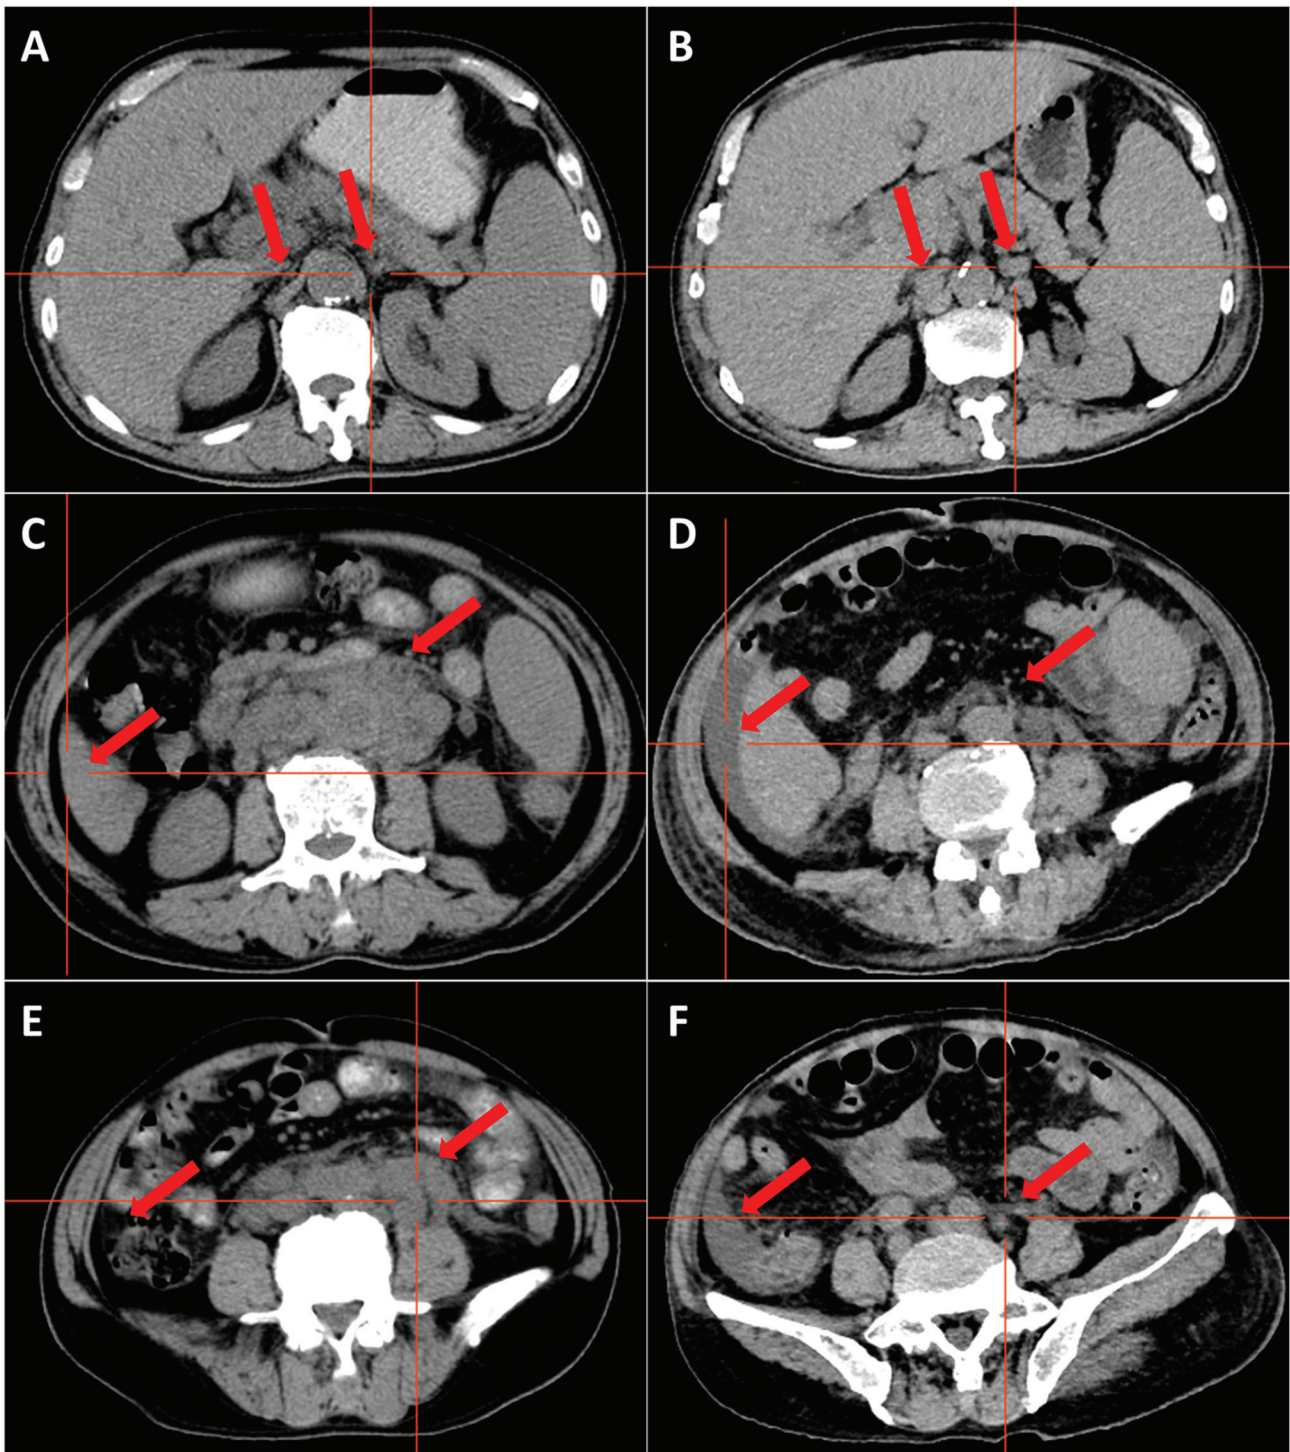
Computed tomography images at first vs. second admission. Lymph nodes behind the pancreas (A) before and (B) after treatment, highlighted by red arrows; no lymph nodes were seen on either side of the abdominal aorta before treatment, and ~6 lymph nodes with a maximum size of 16x8 mm appeared on both sides of the abdominal aorta after treatment. Lymph nodes around the abdominal aorta and retroperitoneum (C) before and (D) after treatment, highlighted by red arrows. Before treatment, there were numerous enlarged lymph nodes adjacent to the retroperitoneal abdominal aorta, some of which were fused to each other, making it difficult to determine the exact number of lymph nodes, the largest of which was 30x20 mm in size. After treatment, the lymph nodes were significantly reduced and some of them had subsided. Ascites (E) before and (F) after treatment, highlighted by red arrows. No ascites was seen before the treatment. Ascites appeared after the treatment.
